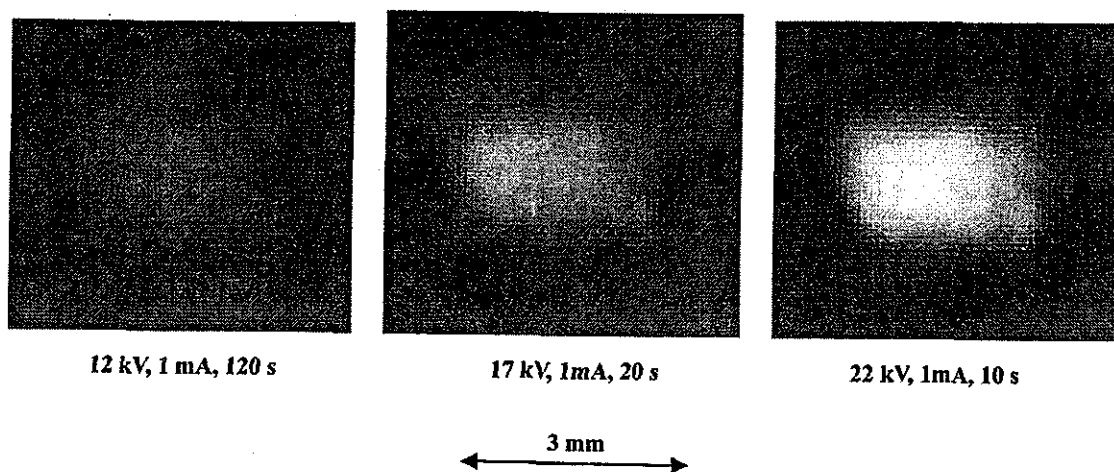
Images of the X-ray source measured by a 50  $\mu\text{m}$ -diameter pinhole with changes in the tube voltage.
